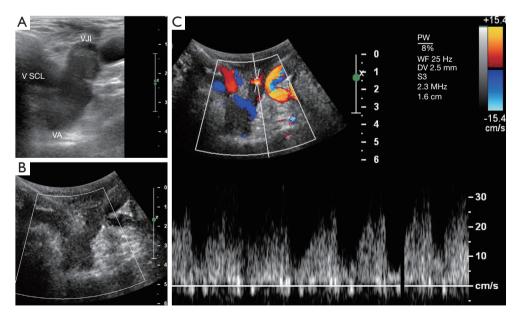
Color and pw-Doppler assessment of the central venous system. Central vein obstruction with completely occluded brachiocephalic vein on B-mode ultrasound (A) and Color-Doppler ultrasound (B). Partial occlusion of the most proximal part of the internal jugular vein with retrograde flow on pw-Doppler (C). VJI, internal jugular vein; V SCL, subclavian vein; VA, anonyma vein; PW, pulsed wave Doppler; WF, wall filter.
